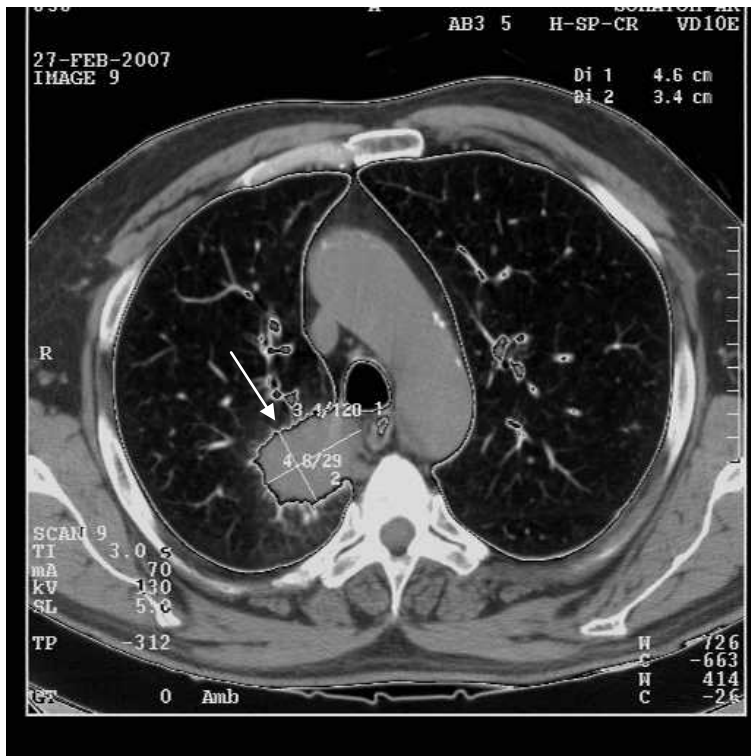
CT-scan on the level of arch of the aorta. In the area of right hilum there is a shadow with irregular contour (arrow). Central cancer of the upper lobe of the left lung when the tumor grows outside the bronchial tube
